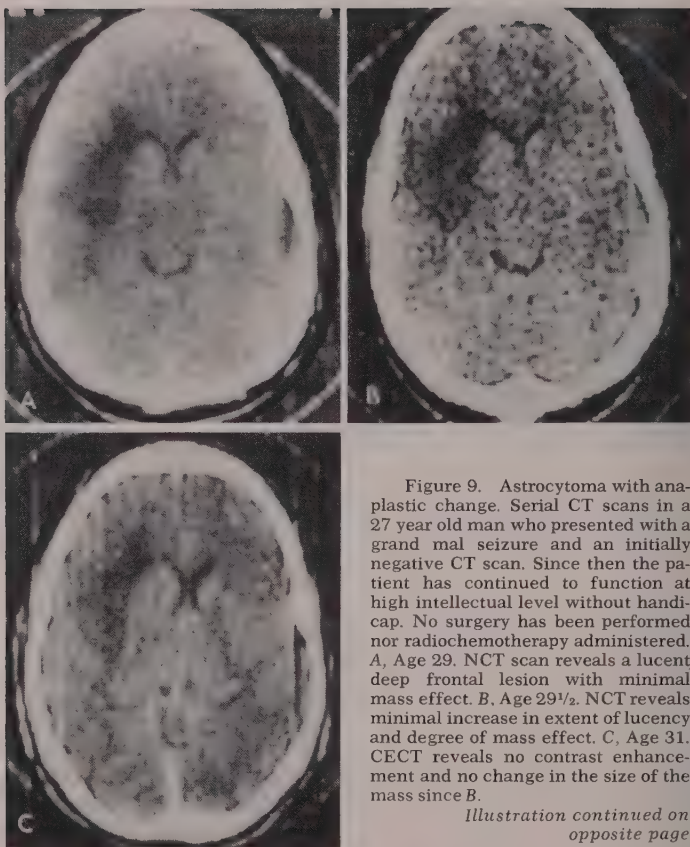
Astrocytoma with anaplastic change. Serial CT scans in a 27 year old man who presented with a grand mal seizure and an initially negative CT scan. Since then the patient has continued to function at high intellectual level without handicap. No surgery has been performed nor radiochemotherapy administered. A, Age 29. NCT scan reveals a lucent deep frontal lesion with minimal mass effect. B, Age 29½. NCT reveals minimal increase in extent of lucency and degree of mass effect. C, Age 31. CECT reveals no contrast enhancement and no change in the size of the mass since B.
